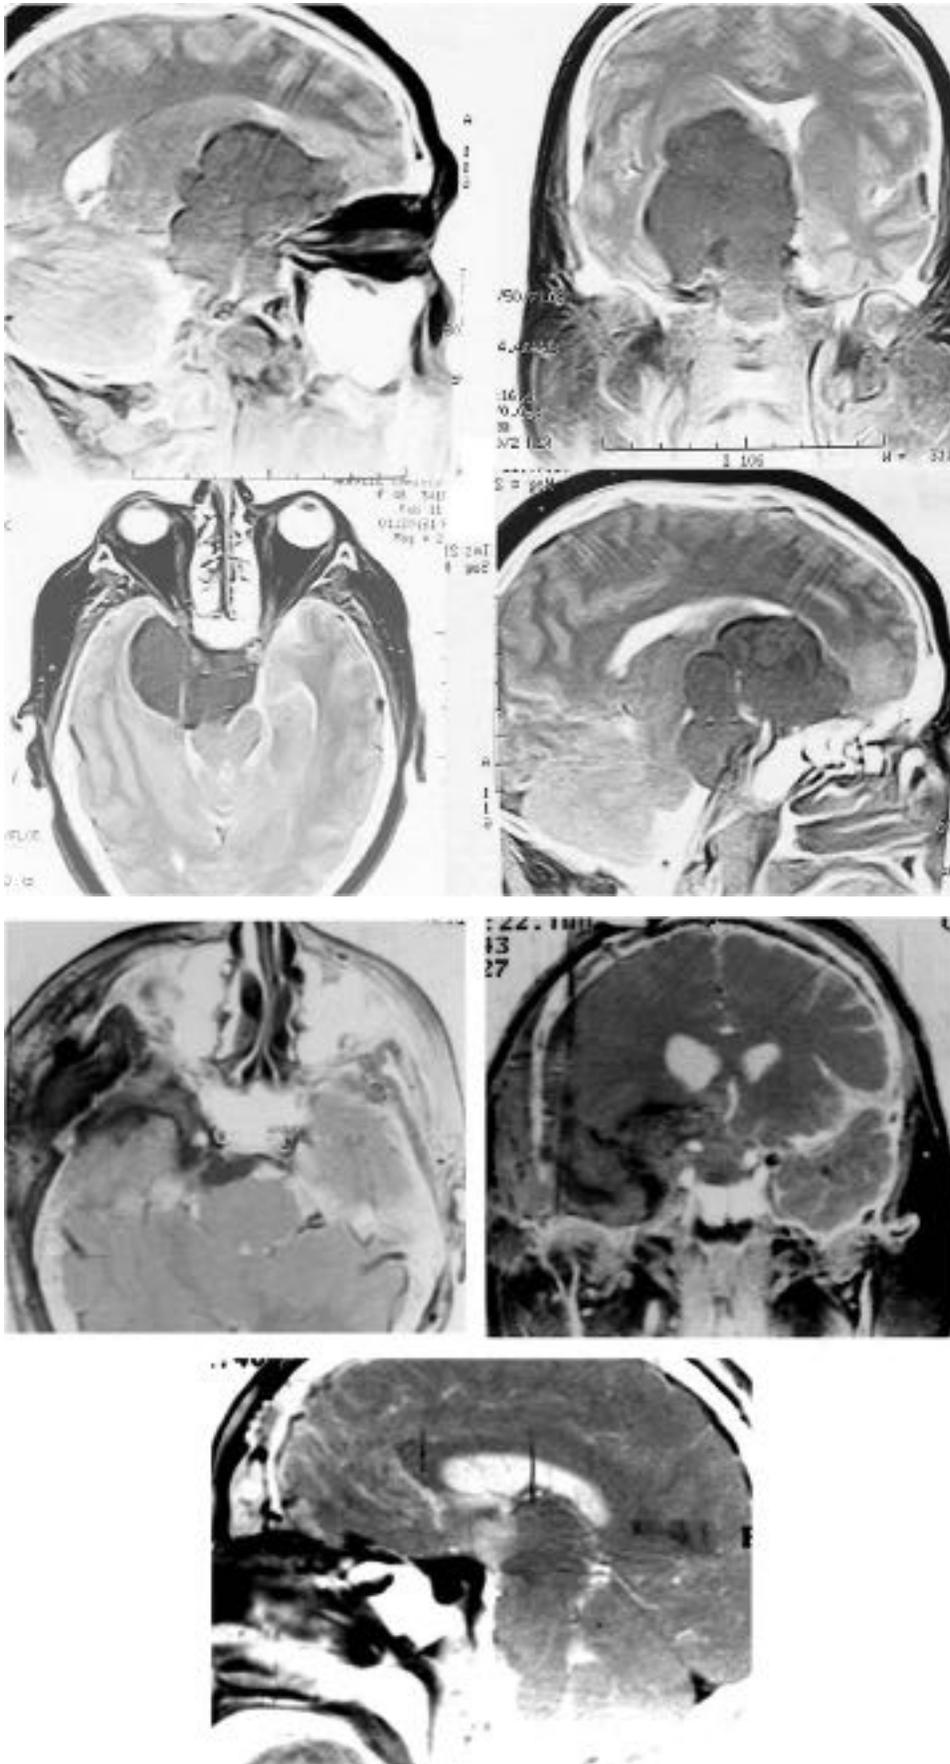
(A) Preop and (B) postop magnetic resonance imaging (MRI) of a giant clinoidal type I meningioma after radical subtotal resection. Pieces of the tumor adherent to the lenticulostriate arteries in the region of the anterior perforated substance were left (coronal MRI). A small piece was also left in the region of the entry site of the abducens nerve (axial cut).
